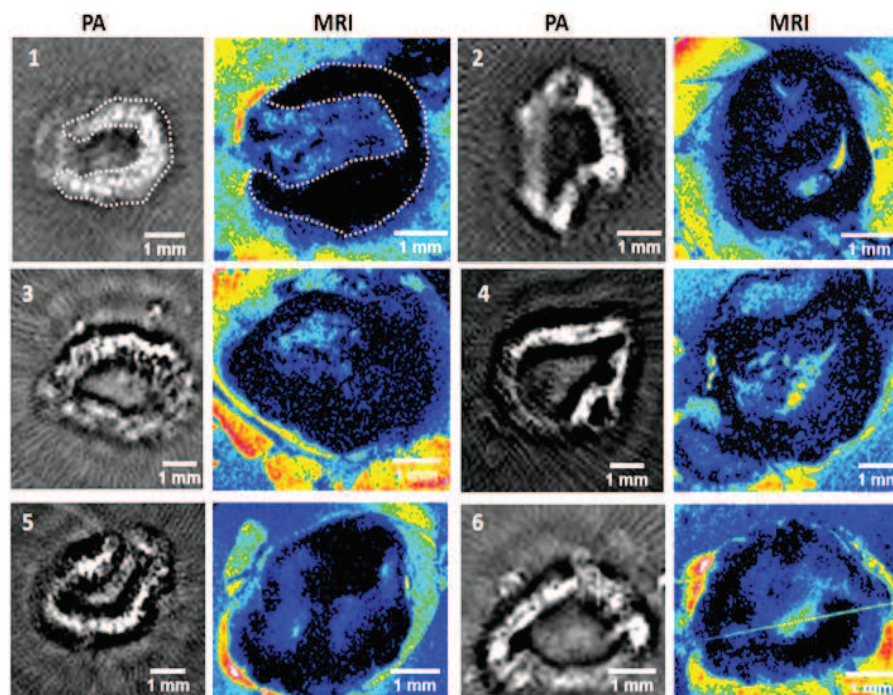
Photoacoustic and MR image comparison of resected lymph nodes with contrast injection. As shown in lymph node 1 (white dotted line), the PA response pattern is comparable with the location of decreased MRI signal. Some nodes show a continuous contrast band throughout their periphery (1,5), while others show some small irregularities (4,6).^[164]
